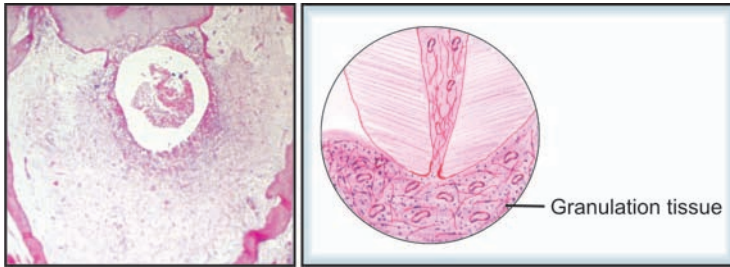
Periapical granuloma (chronic apical periodontitis)
